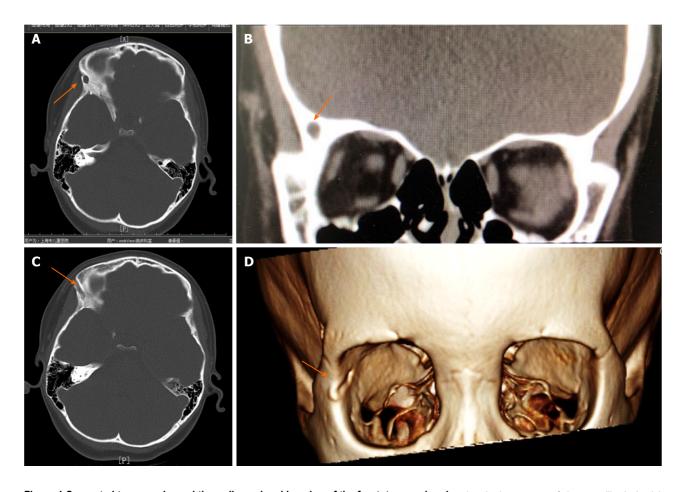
Computed tomography and three-dimensional imaging of the frontotemporal region. Local subcutaneous soft tissue swelling in the right temporal region was noted. Computed tomography value was about 31 HU. The shape, size, and position of the ventricle system were normal, and no obvious bone destruction or other abnormal changes were observed in the remaining skull. A-C: Computed tomography images; D: Three-dimensional imaging. Orange arrows indicate the fistula.
